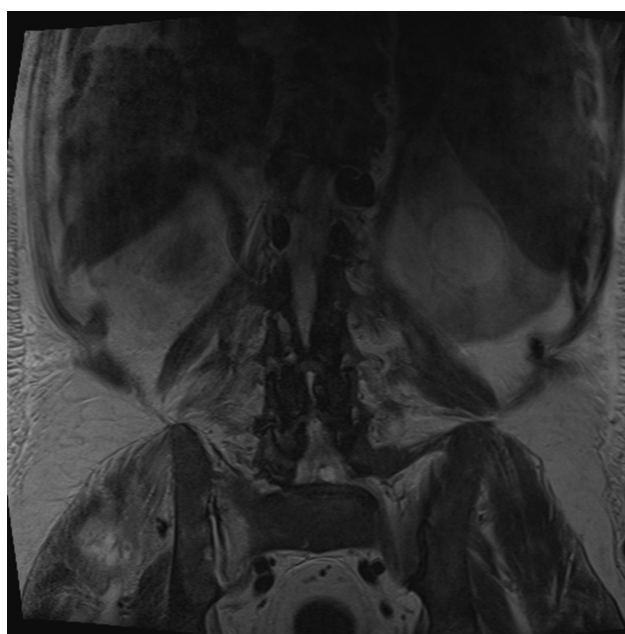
MRI of the column: right sacroiliitis signs and ipsilateral gluteal collections.
